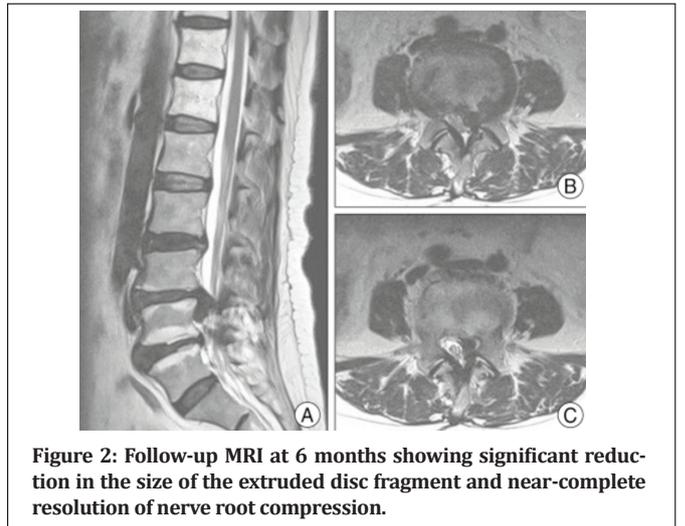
Follow-up MRI at 6 months showing significant reduction in the size of the extruded disc fragment and near-complete resolution of nerve root compression.
